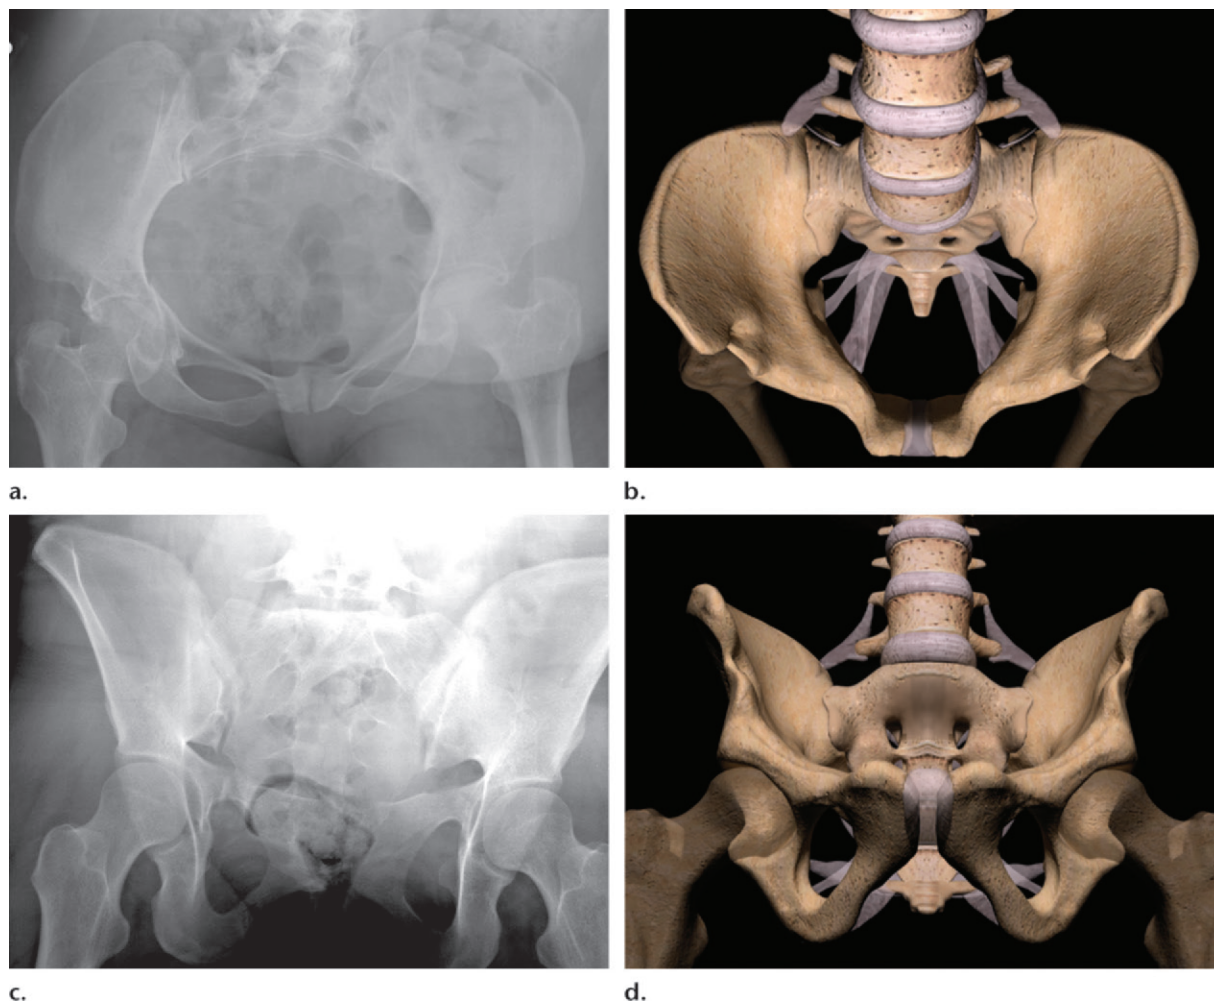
(a, b) Inlet radiograph (a) and corresponding computer-generated image (b), obtained with the beam oriented 30°–60° caudally through the pelvis and the patient lying supine, show the pelvis. These images help detect anterior or posterior displacement of bony pelvis structures, rotational deformities, sacral arch fractures, and sacral crush injuries. (c, d) Outlet radiograph (Ferguson view) (c) and corresponding computer-generated image (d), obtained with the beam oriented 25°–45° cephalad and perpendicular to the sacrum, show the pelvis. These images help detect sacral fractures, SI joint widening, and hemipelvis elevation.
